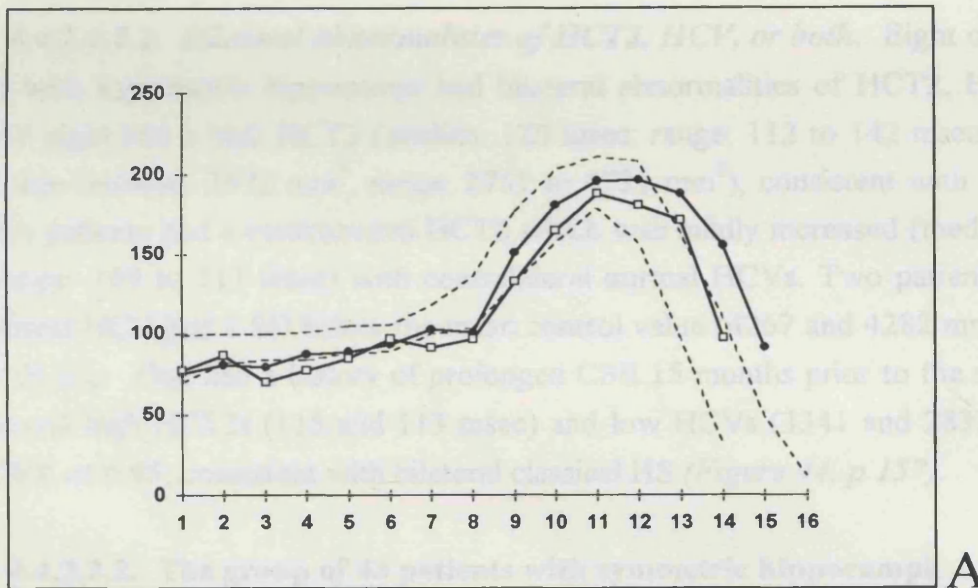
Probable dysgenesis of right hippocampus. Patient was a 27 year old woman with epilepsy since the age of 11 years. There was no history of FC or meningo-encephalitis. Clinically, she had TLE which was confirmed on video-EEG. Dystonic posturing of the left arm and automatisms of the right arm suggested right temporal onset. Interictal and ictal EEG showed a clear right temporal focus. Visual assessment of her MRI scan was unrevealing. The quantitative MRI however was unusual. The anterior part of the right hippocampus appeared larger than the left (A) (see sections 9, 12, and 14 in C) and had an increased HCT2, which was not sufficiently prolonged to be evident on visual assessment of the HCT2 map (B). These findings would be unusual for HS, and may represent dysgenesis of the right hippocampus. $HCVR(L/R) = 0.86$ ($NI \geq 0.87$); HCV right = 5584 mm^3 , HCV left = 4830 mm^3 ($NI: \geq 4348 \text{ mm}^3$); $HCT2$ right = 112 msec, $HCT2$ left = 106 msec ($NI \leq 108$ msec). On the HCV distribution graph, the black circles represent the right hippocampus and the open squares the left hippocampus. [Hospital number: QSC37619].
